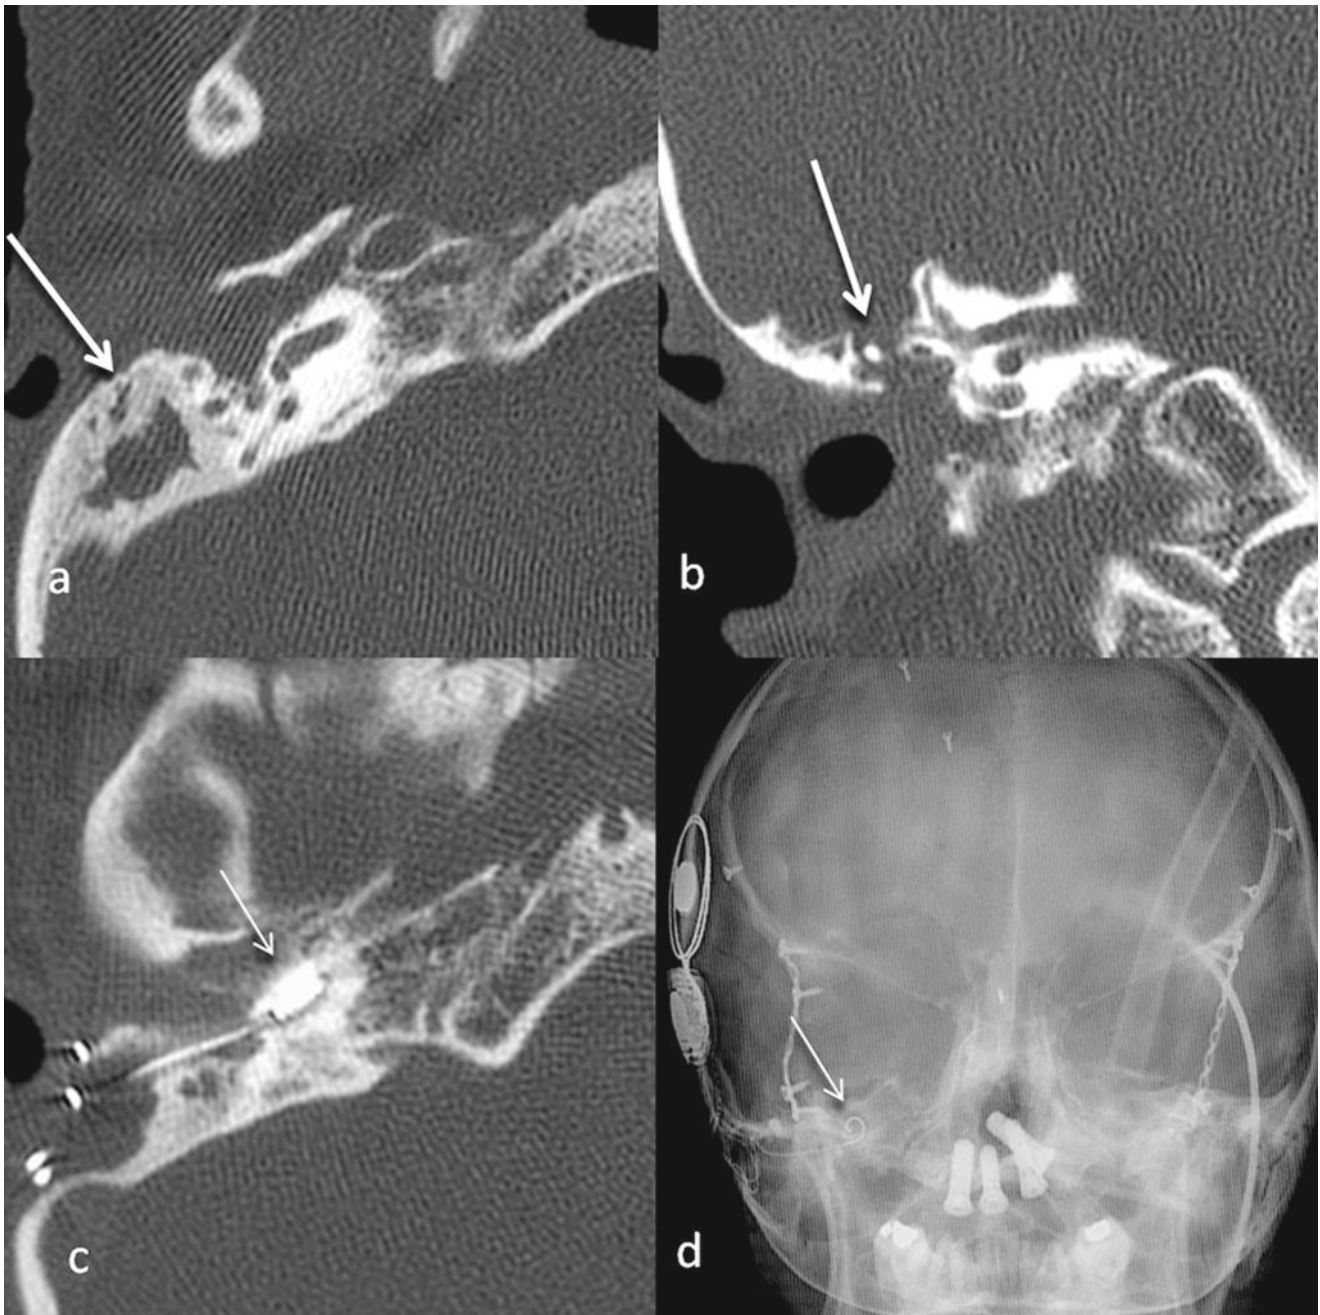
Child with acquired hearing loss due to radiation therapy needed to treat nasopharyngeal rhabdomyosarcoma. Preoperative axial (a) and coronal (b) CT demonstrates extensive bone destruction
